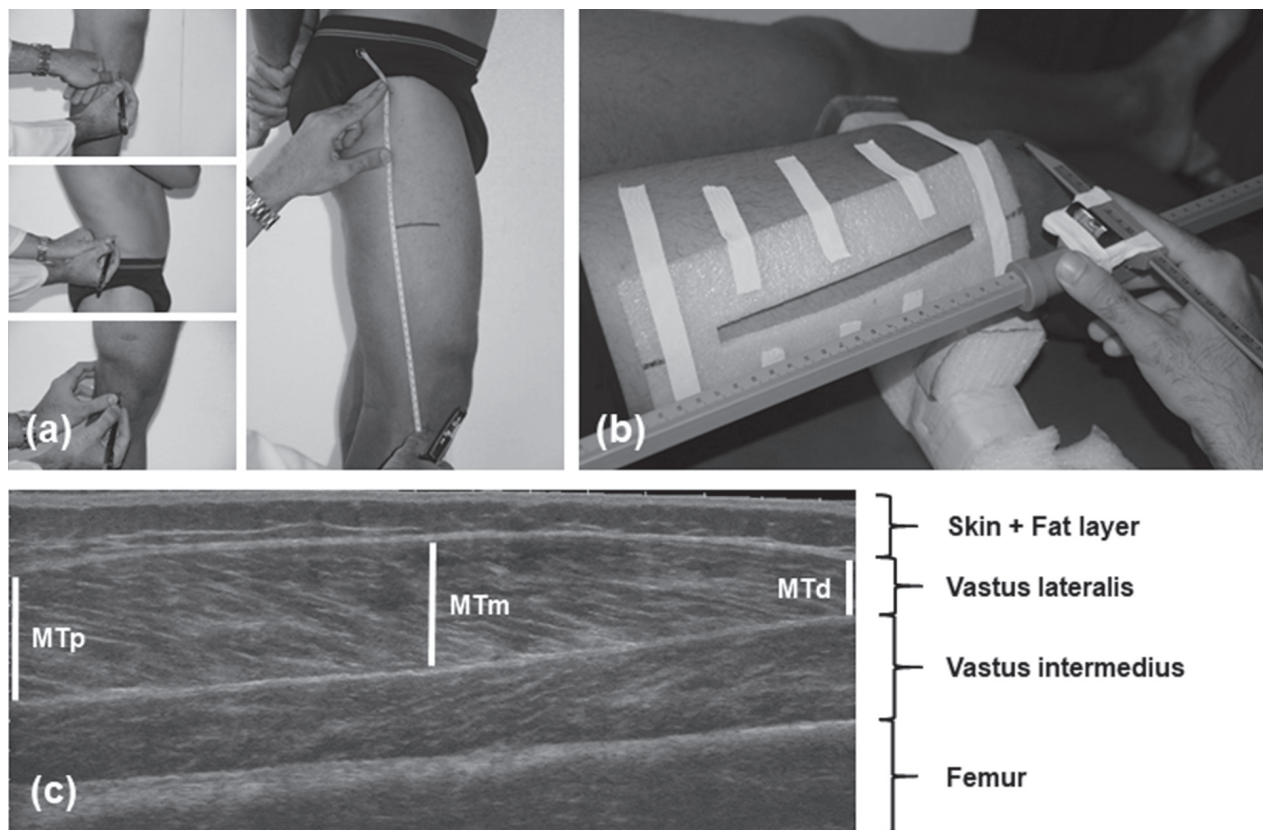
Marking of anatomical landmarks (a); positioning of the guide rail (b); panoramic ultrasound image with measurements of muscle thickness in the proximal (MTp), medial (MTm) and distal (MTd) portions (c).
